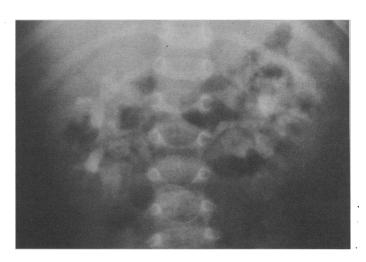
Case 1. Film at one hour showing pronounced increase in density of pyramids, with lesser increase in density of remainder of kidney. Continuing calix opacification. (At this study there was no measurable change in kidney size on the original radiographs.)
